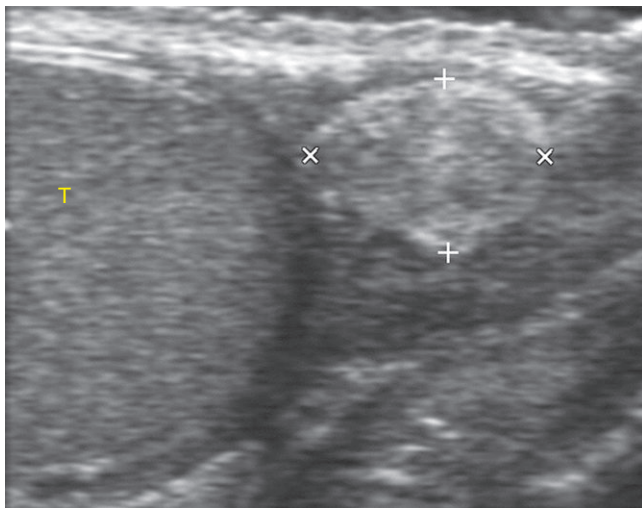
Ultrasound of the scrotum shows an echogenic extra-testicular mass (calipers) within the epididymis. (T=testis.)
